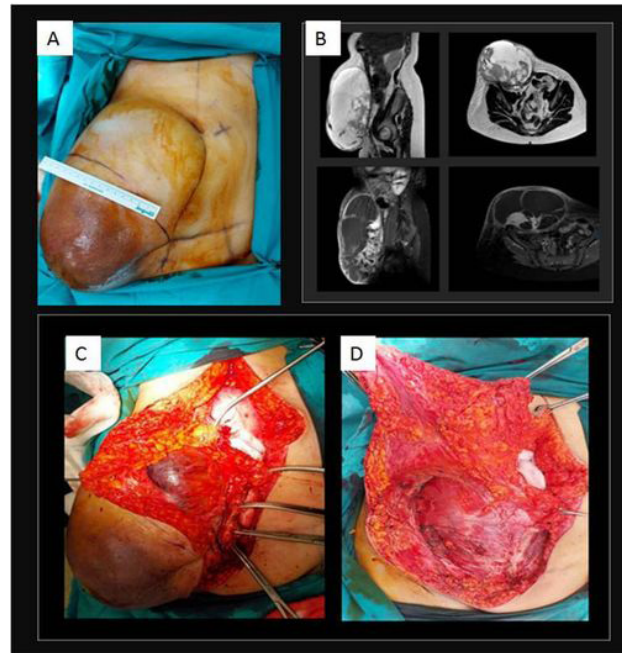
(A) Preoperative photograph of the tumoral mass. (B) Magnetic resonance imaging revealed tumour invasion of the abdominal wall and anterior rectus fascia. (C) In surgery, vertical and groin incisions were made, and the tumoral mass was removed with the anterior rectus fascia and the infiltrated skin tissue. (D) Complete resection of the tumour resulted in a large skin defect and dead space in the surgical area
